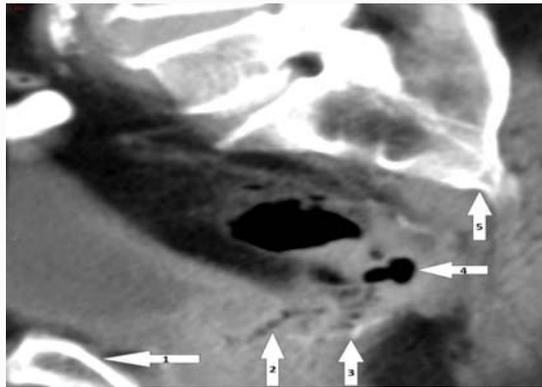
Oblique-sagittal reconstruction Computed Tomography imaging demonstrating fistula tract between neo-rectum and seminal vesicle. (1. Pubic symphysis, 2. Fistula tract 3. Anastomosis staple line, 4. Neo-rectum, 5. Sacrum).
